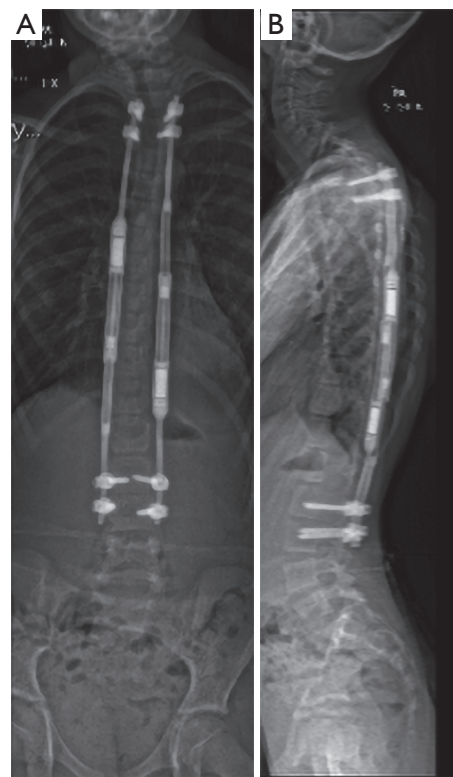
Standing posteroanterior (A) and lateral (B) spinal radiograph after surgery using magnetically controlled growing rods. Fixation points using pedicle screws.
